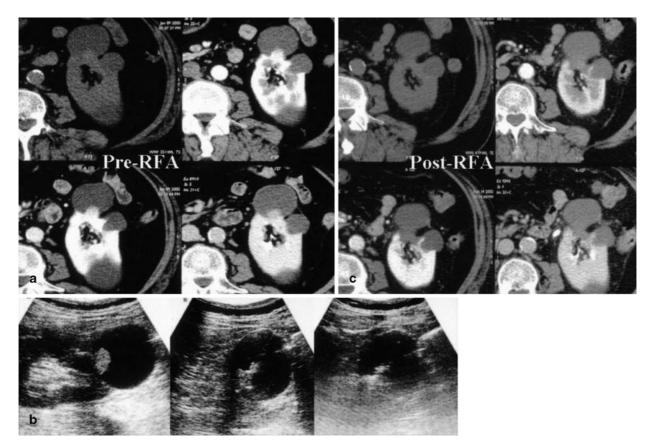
Patient no. 8, elderly, with prostate cancer and left solitary kidney, developing a very small RCC exophytic towards the lumen of a subcapsular cyst. a Multi-phase CT before b US-guided transperitoneal transcystic RFA, and c after the treatment
